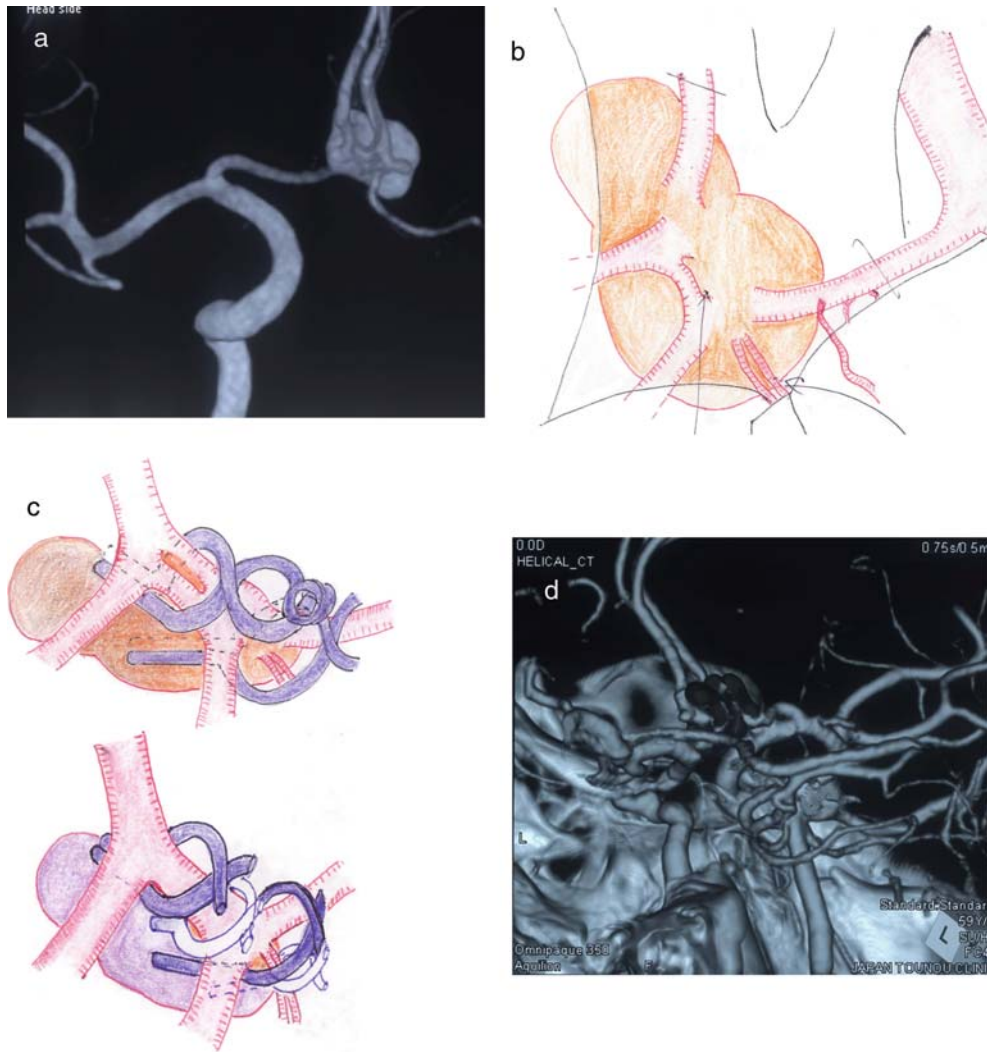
(a) CT Angiography showing a Complex ACom Artery Aneurysm (b) Complex Acom artery Aneurysm (c) Precise clipping using appropriate multiple clips with preservation of perforators (d) Post operative CT Angiography showing the Complex ACom Artery Aneurysm to be excluded from the circulation with perforators preserved
